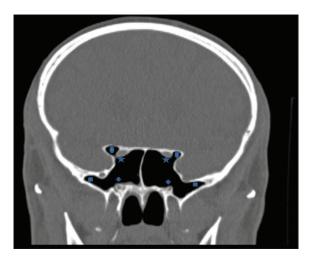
Coronal computed tomography image of paranasal sinuses showing pneumatization of anterior clinoid process (squares), protrusion and dehiscence of optic nerves (circles), protrusion of vidian canals (arrowheads) and pneumatization of pterygoid process (asterisks)
